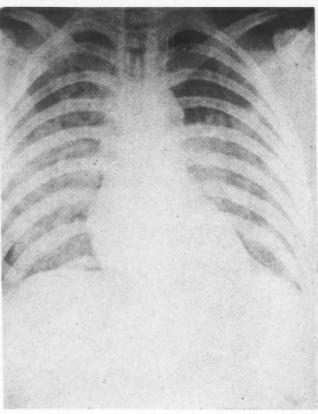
January 12, 1959. Radiograph was taken four hours postoperatively. The radiological appearance is quite similar to that in Fig. 2.
